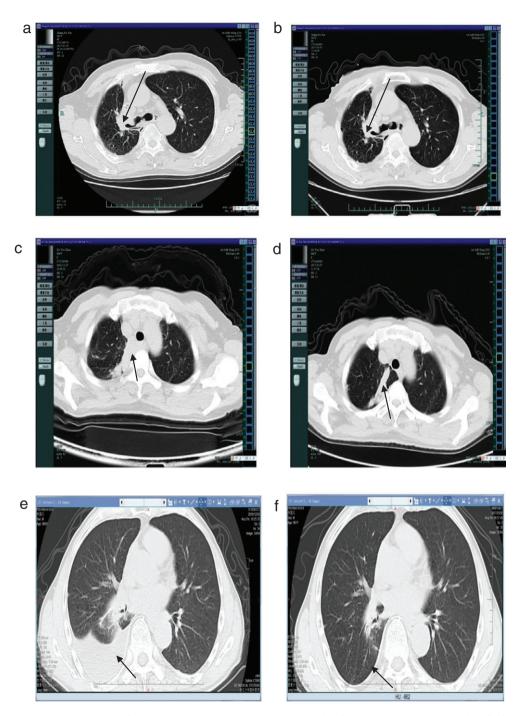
Computed tomographic images from patients I, II, and III show the mass(a,c,e) before apatinib treatment, and (b,d,f) after three months of apatinib therapy, respectively.
